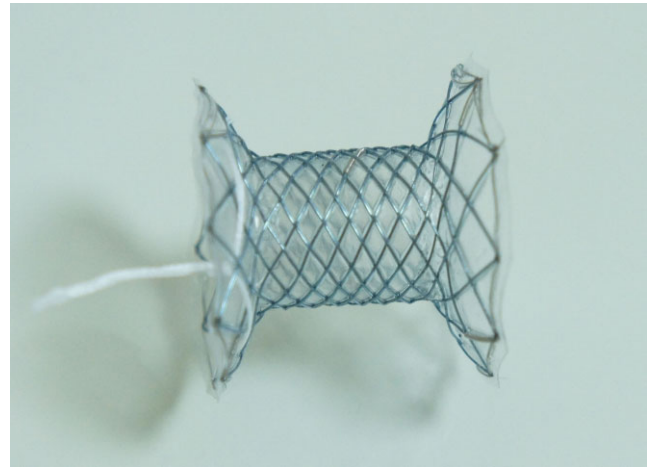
A novel biflanged metal stent that was designed for endoscopic ultrasound (EUS)-guided Drainage (Nagi stent, Taewoong Company, Seoul, Korea)
